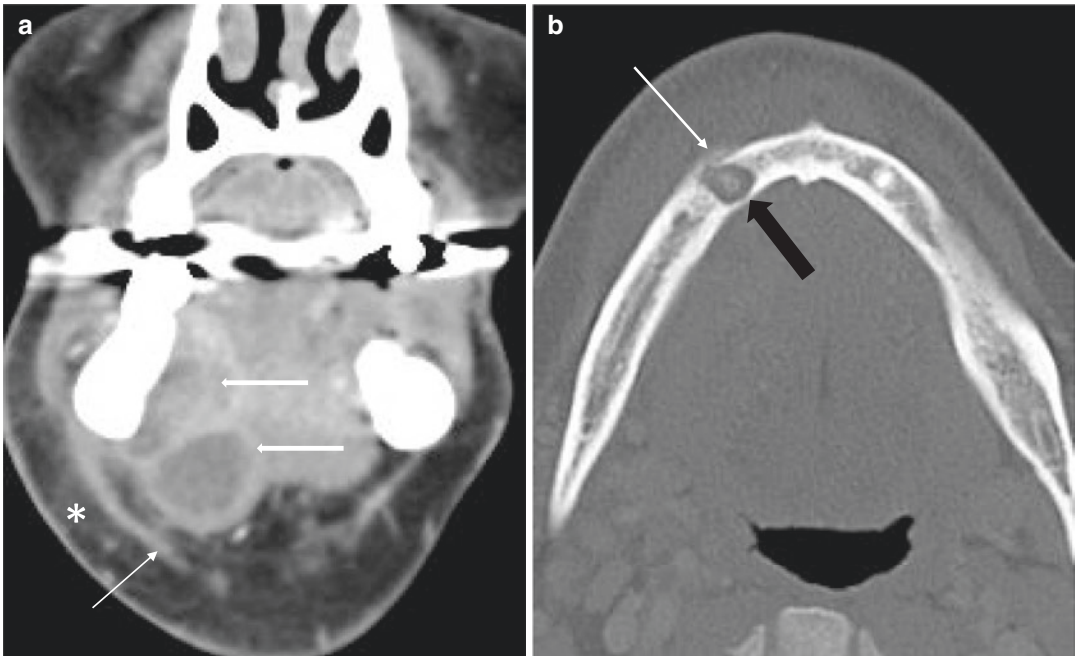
(a) Coronal CECT soft tissue window showing a rim enhancing abscess in the right floor of mouth (thick white arrow). Overlying thickening of the platysma (thin white arrow) and subcutaneous fat stranding (asterisk). (b) Axial CT bone window showing periapical lucency surrounding the root of the lower right second tooth (thick black arrow) with overlying periosteal reaction (thin white arrow)
